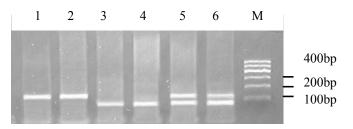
Result of PCR-RFLP (1,2 were genotype TT; 3,4 were genotype CC; 5,6 were genotype CT;M was 100bp DNA ladder)
